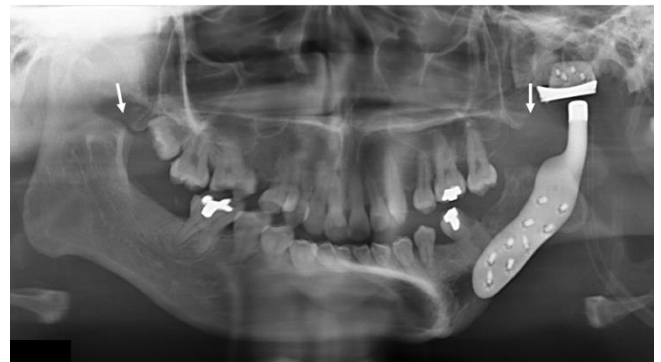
Postoperative panoramic radiograph showing the complete resection of both coronoid processes (arrows); the presence of a metal reconstruction plaque extending from the left mandibular body, angle and ramus; and a prosthetic mandibular condyle.
